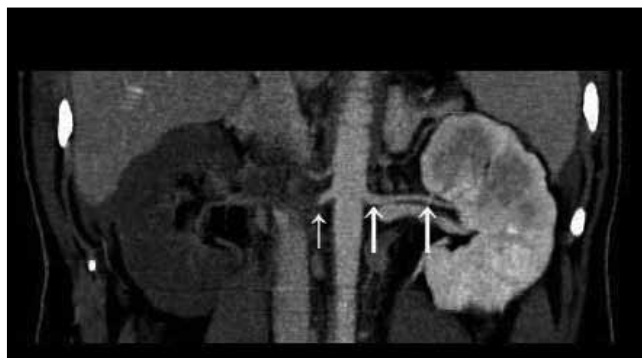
Coronal CT image shows abrupt cut-off of the right renal artery (single small arrow). The left renal artery is normal in calibre and shows good contrast opacification (thick double arrows).
